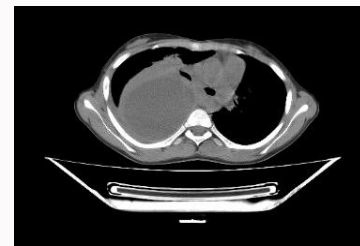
Contrast Enhanced Computed Tomography (CECT) scan Well defined cystic lesion in right lower lobe causing collapse of right upper & middle lobes with mediastinal shift towards left.
